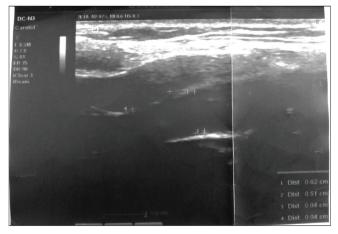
Doppler scan of carotid arteries with measurements from our study
